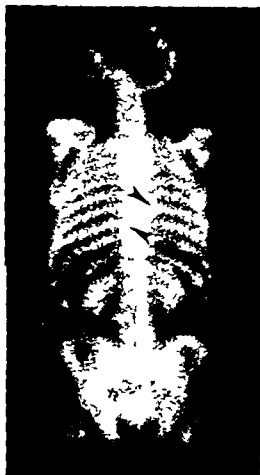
Skeletal scintigraphy using 99m technetium diphosphonate. Increased uptake of the radionuclide is seen in two vertebral bodies (arrows), several ribs, one shoulder, denoting an area of accelerated skeletal
